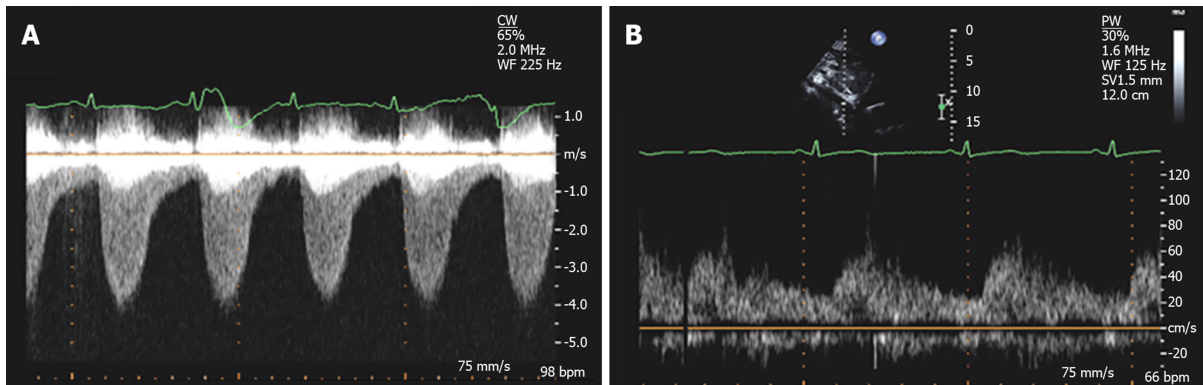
Doppler echocardiographic findings in coarctation of aorta. A: Continuous wave Doppler across the coarctation segment in suprasternal view demonstrating significant increase in flow velocity with a peak velocity of 4 m/s, comparable to a peak gradient of 64 mmHg based on simplified Bernoulli's equation; B: Abnormal Doppler pattern in abdominal aorta in a patient with severe coarctation demonstrating blunted velocity with delayed systolic upstroke and continuous diastolic run-off.
